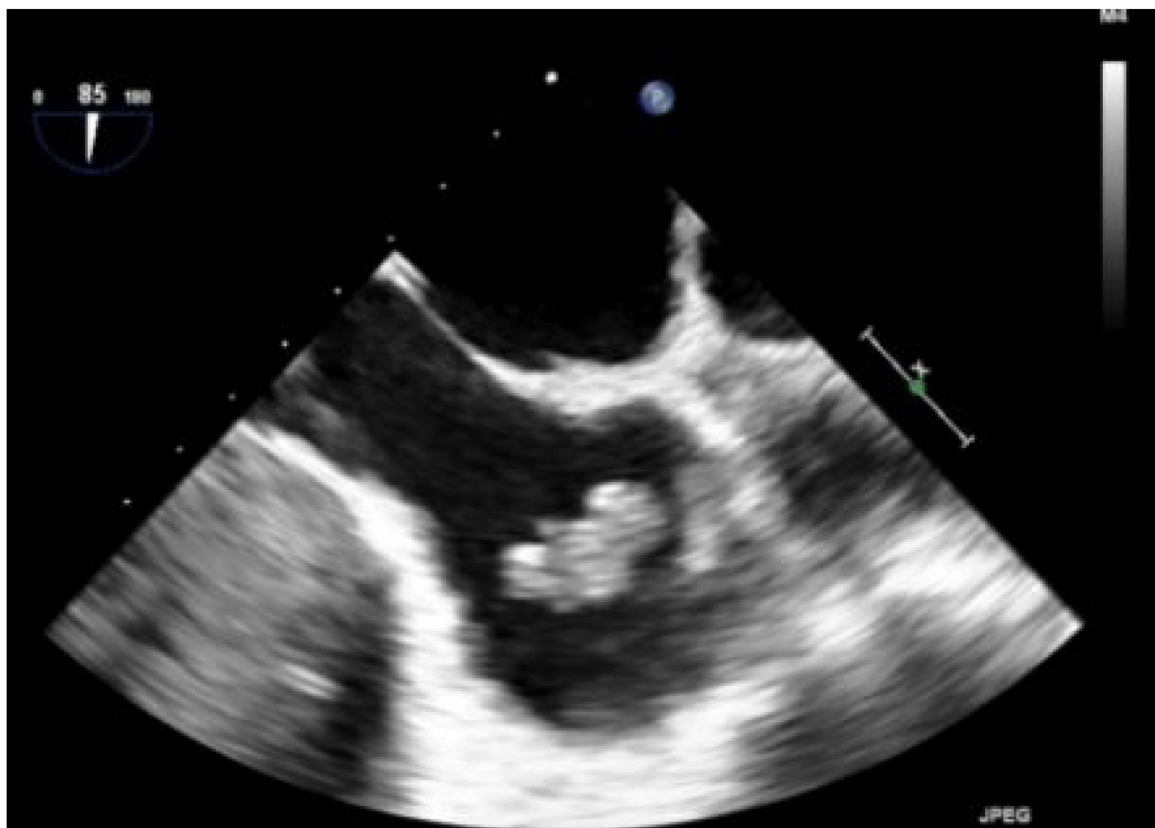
Transesophageal Echocardiogram: Large mobile superior vena cava mass.
